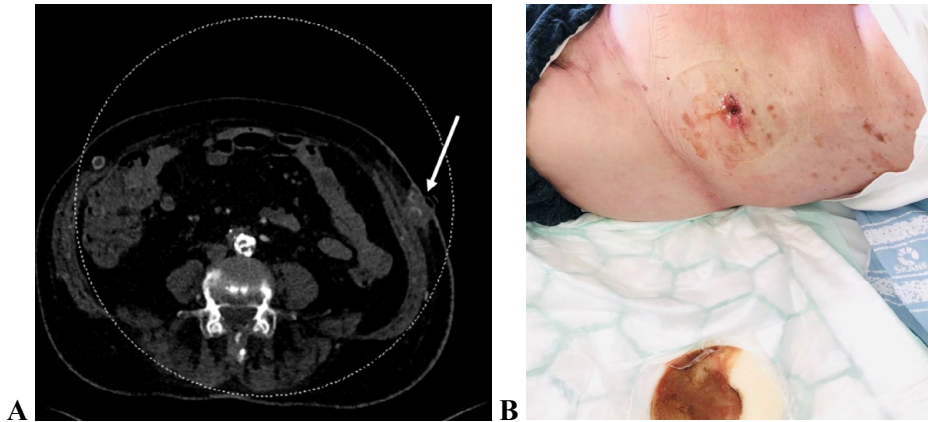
Computed tomography angiography revealed an infected left-sided axillofemoral synthetic bypass (arrow). The severity of SSI is Szilagyai grade III. Figure 4B. Shows the infected site that has oozed pus into the wound dressing. Copyright: Stefan Acosta.
